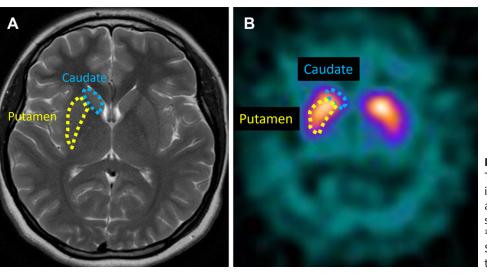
Anatomy of the striata. Axial T2-weighted MR (A) and ¹²³I-ioflupane SPECT (B) images show the caudate (blue dashed outline) and putamen (yellow dashed outline). The striatum appears as a continuous structure on ¹²³I-ioflupane SPECT images. Because of limited SPECT resolution, it is challenging to delineate the caudate and putamen.
